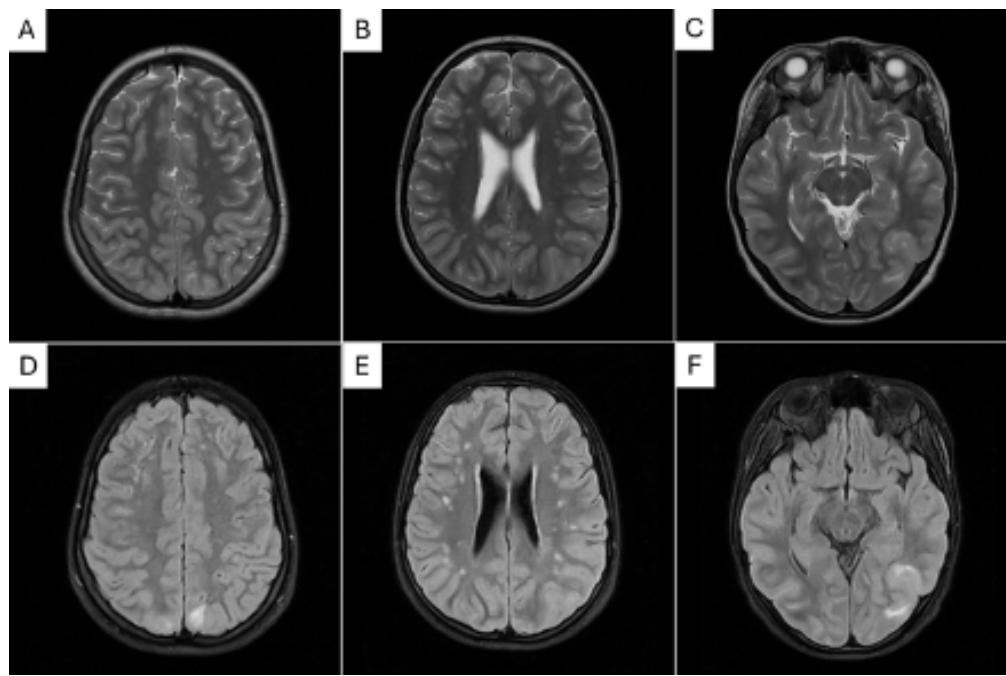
Brain MRI performed on day 8
